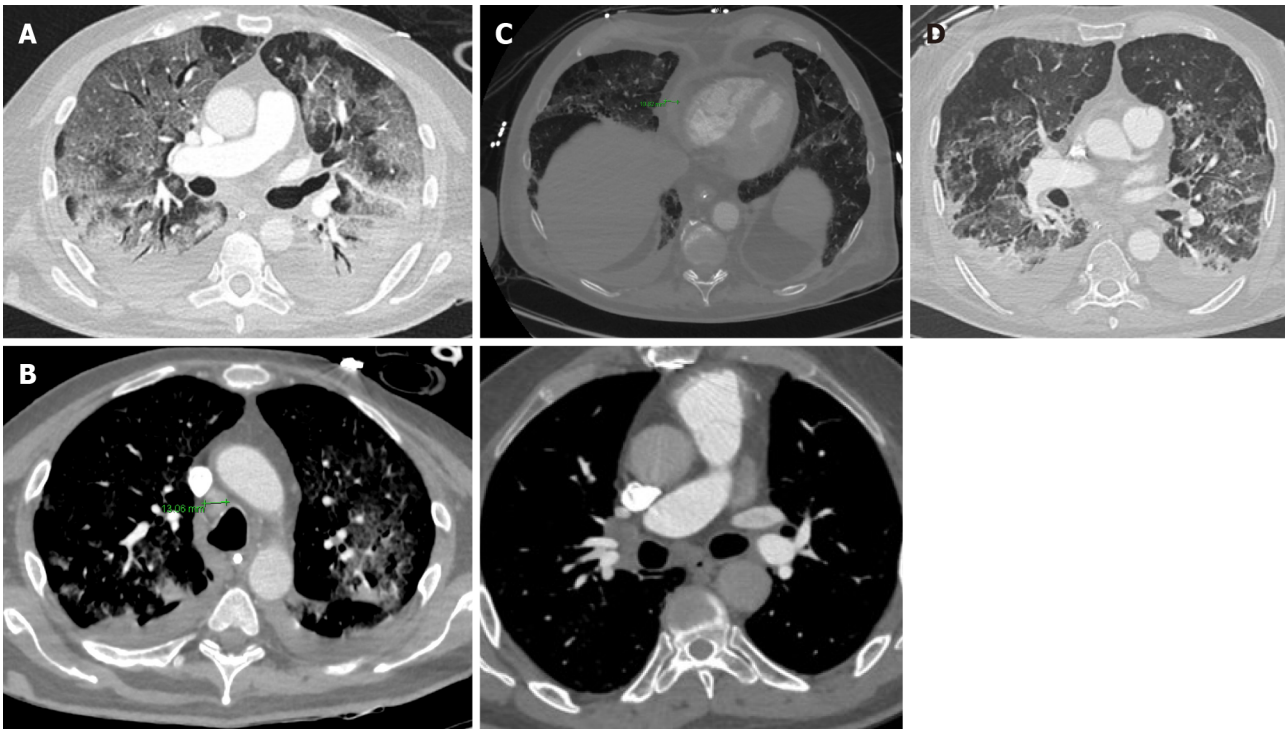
Unusual chest computed tomography findings in coronavirus disease 2019 pneumonia. A: Air bronchogram sign; B: Right paratracheal lymphadenopathy (marked) and right hilar lymphadenopathy; C: Pericardial effusion; D: Pleural effusion.
